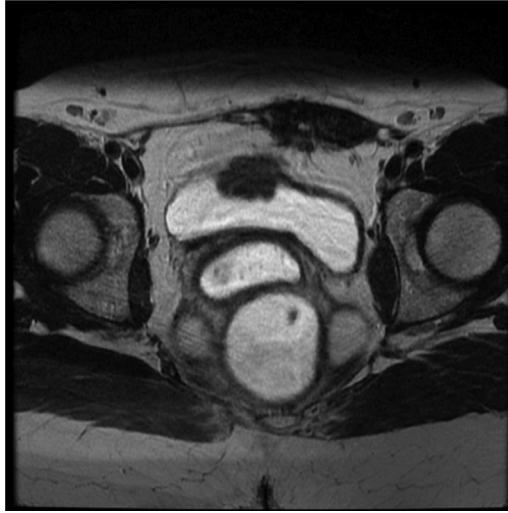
MRI image with AWE and concurrent bladder endometriosis nodules.
